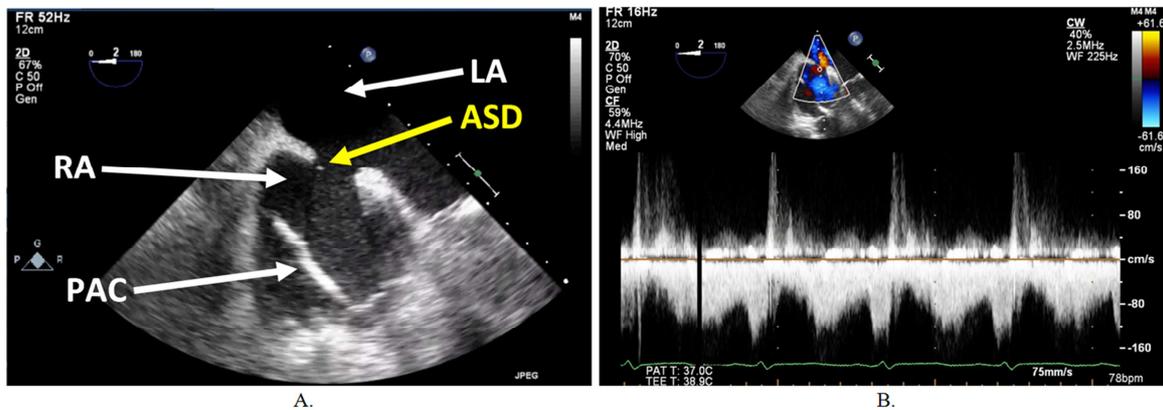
Transesophageal Echocardiography Images Obtained After Anesthesia Induction.
